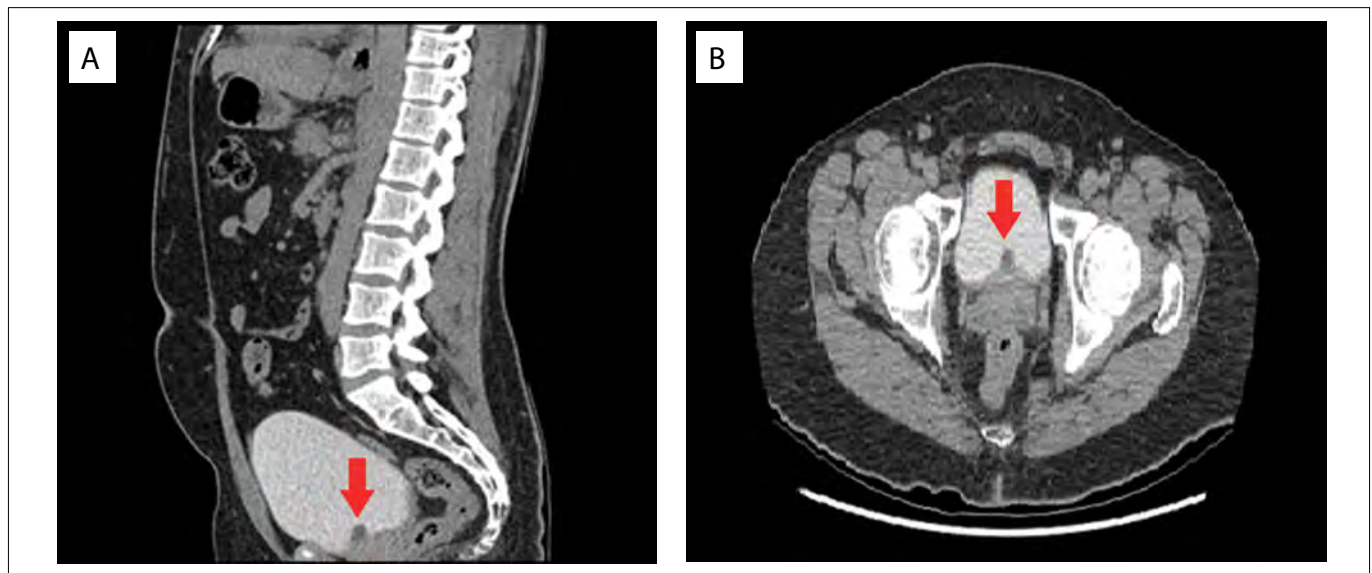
Sagittal (A) and axial (B) computed tomography urography images showing low-density small nodular lesion in the bladder neck that represents the anteriorly positioned midline prostatic cyst (arrow).
